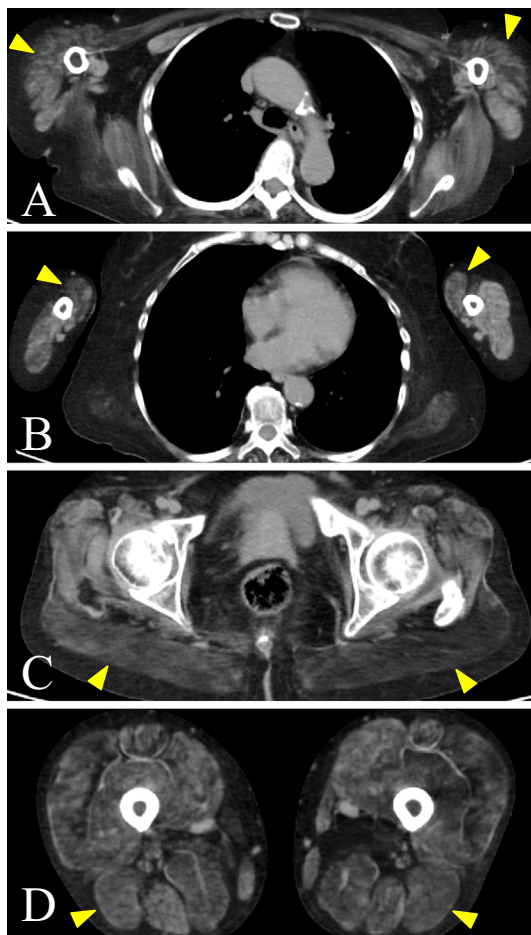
Skeletal muscle computed tomography (CT). Skeletal muscle CT demonstrates asymmetric atrophy in the bilateral deltoid muscles (A, arrowheads), biceps brachii muscles (B, arrowheads), gluteus maximus muscles (C, arrowheads), and hamstring muscles (D, arrowheads).
